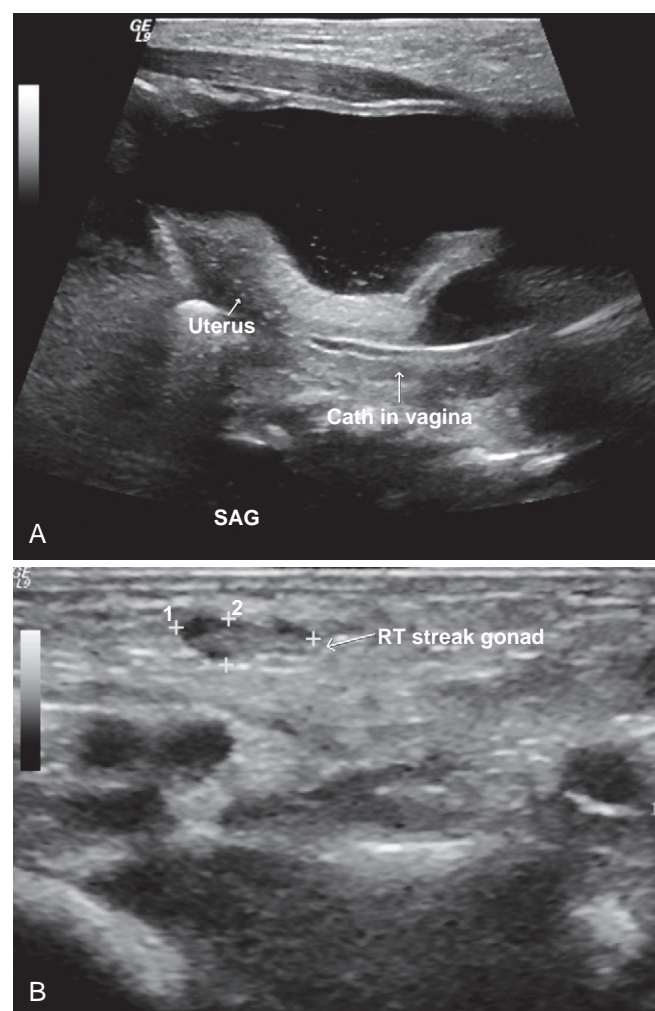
A, Pelvic ultrasound in a patient with mixed gonadal dysgenesis demonstrating the bladder, a catheter inside the vagina, and the uterus. B, Ultrasound of the right inguinal region ultrasound showing a streak gonad.
